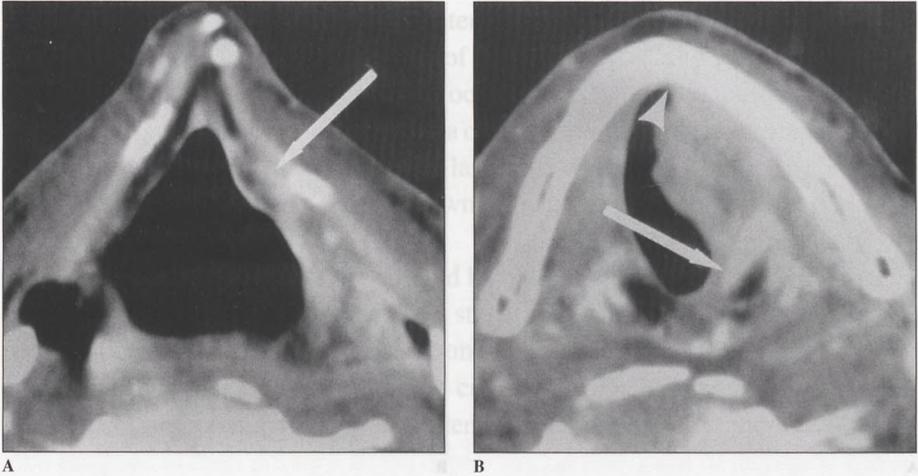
CT scan of a patient with a 4.3-cm³ carcinoma of the left true vocal cord and a tumor score of 6. (A) Image at the false cord level demonstrates involvement of the left aryepiglottic fold and obliteration of the paraglottic space (arrow). (B) Image at the true vocal cord level demonstrates a bulky lesion that involves the entire cord, extends just onto the anterior commissure (arrowhead) as well as the face of the ipsilateral arytenoid (arrow) and obliterates the paraglottic space.
